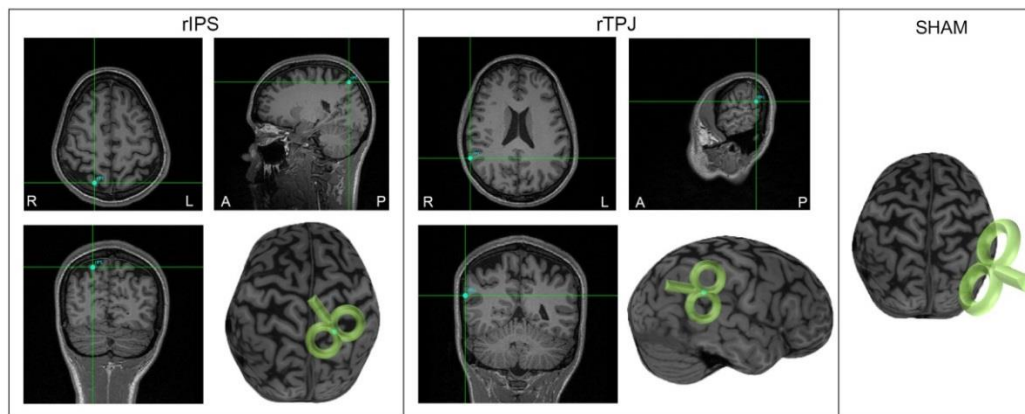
TMS coil orientation and localization of right intraparietal cortex (rIPS), right temporo-parietal junction (rTPJ) and sham stimulation for an example participant. (R=Right; L=Left; A=Anterior; P=Posterior). Slices represent sagittal-, transverse- and coronal- views (T1 structural MRI scans) as well as 3D surface reconstructions of the brain.
